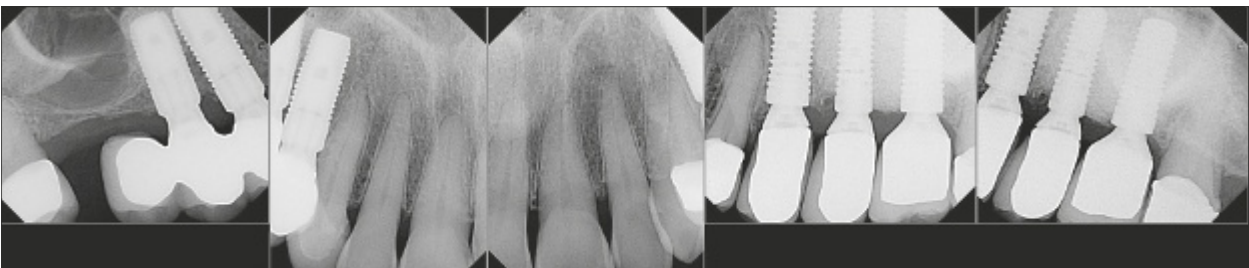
Final radiographs obtained after 3 months.
